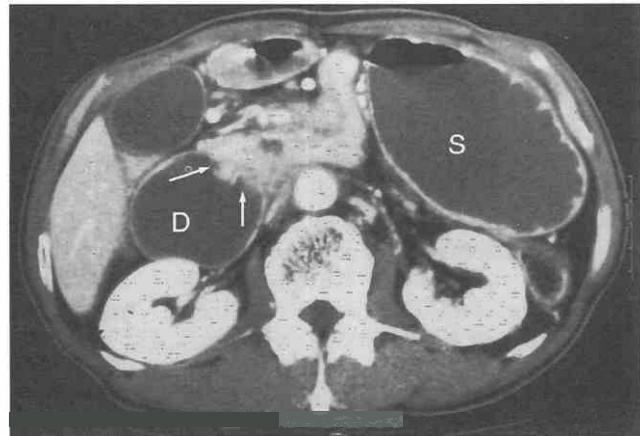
Duodenal obstruction caused by direct tumor invasion of pancreatic cancer into third portion of the duodenum. CT scan shows irregular soft tissue mass (*arrows*) obstructing the duodenum (D) with marked distention of the stomach (S). Pancreatic cancer is not shown.
